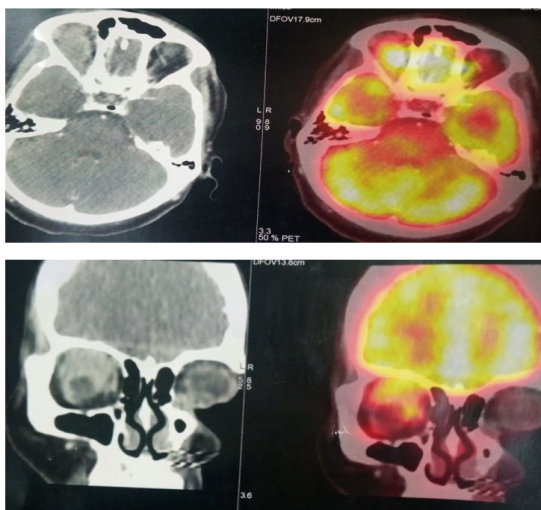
PET-CT Scan Showing Right Sided Orbital Metastasis-July 2021
